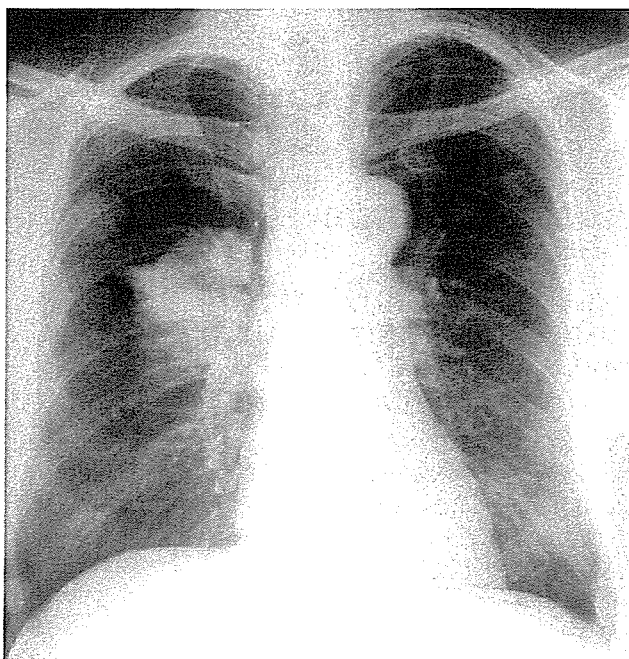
Plain chest X-ray showing a large metastatic mass in the right hilar region and multiple metastases in both lungs.
